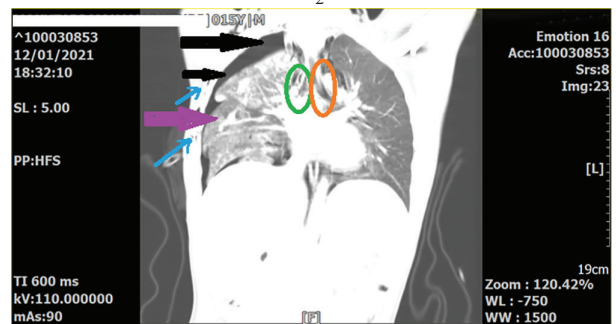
Coronal view of the chest CT on lung window shows right-sided subcutaneous emphysema (blue arrows), right pneumothorax (black arrows), and partially collapsed lung (purple arrow). The left main bronchus silhouette is intact (brown circle), while the outline of the right main bronchus is disrupted, and mild displacement occurs (green circle).
